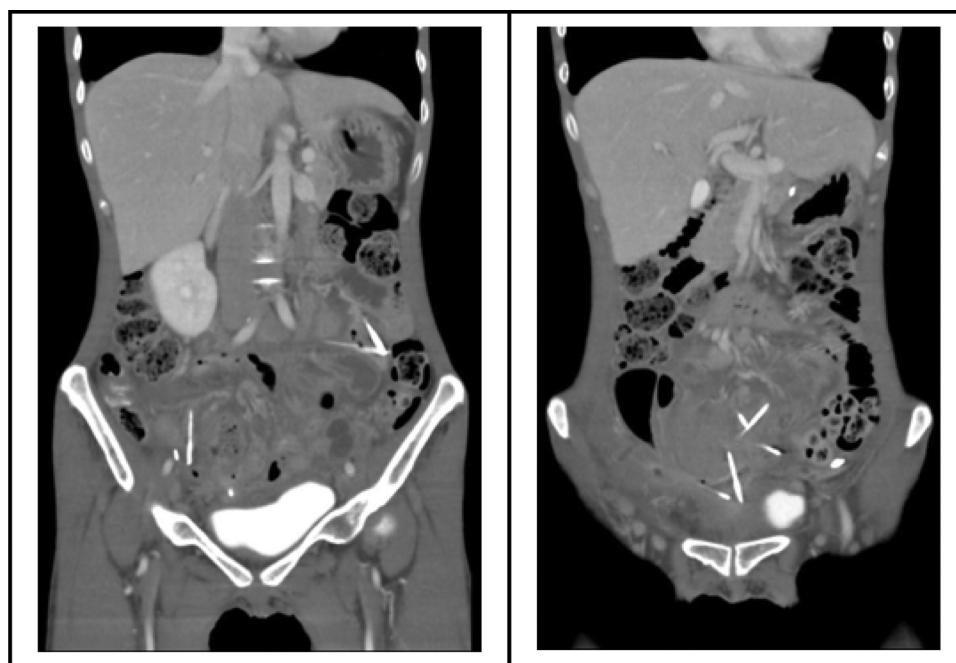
CT scan shown multiple metallic long thin needles disseminating throughout the digestive tract.
